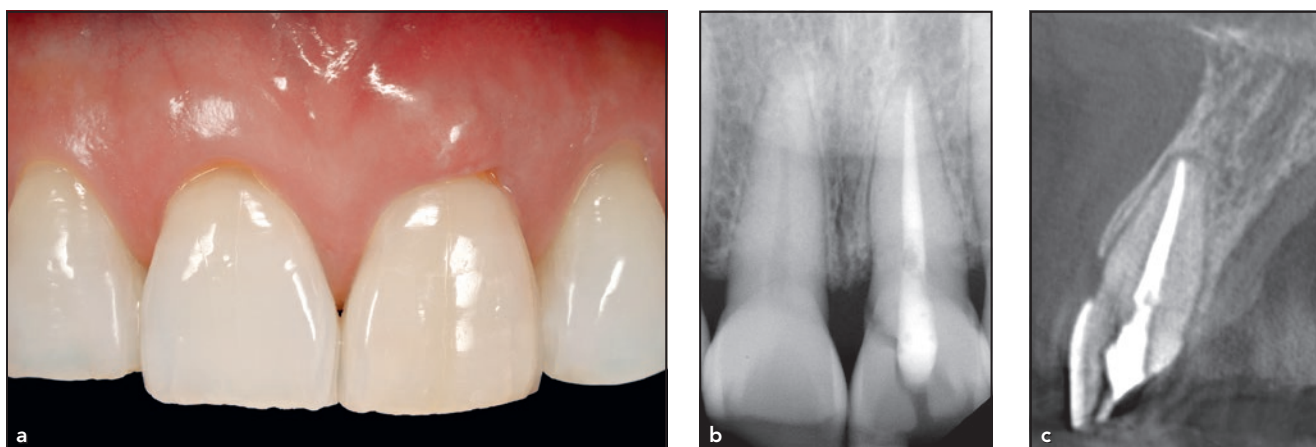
Case 1. (a) Facial view of the maxillary left central incisor with a vertical crown, root fracture, and a periodontal abscess at the free gingival margin. The sounding depth was 4.5 mm to the bone crest, indicative of 1.5 mm of bone loss. (b) Periapical and (c) CBCT radiographs show a subosseous root fracture on both the facial and palatal aspects.
